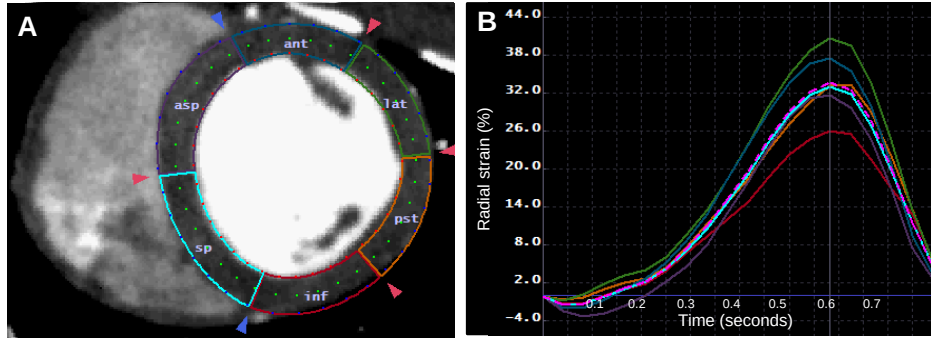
Multi-Modality Tissue Tracking (MTT) Analysis for Multidetector Computed Tomography (MDCT) Images. (A) American Heart Association (AHA) segmentation of middle LV short axis into anterior (ant), anterior septal (asp), inferior (inf), lateral (lat), septal (sp) and posterior (pst) segments at end-diastole and (B) strain curve. The y-axis represents percentage radial strain. The x-axis represents time during the cardiac cycle. Tracing of endo- and epi-cardial borders was performed at end diastole.
